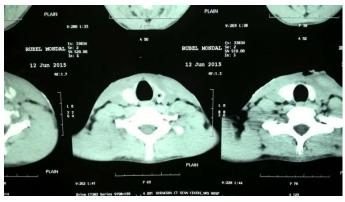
CT scan of neck shows a fistula tract running along postero-medial to left lobe of thyroid.
